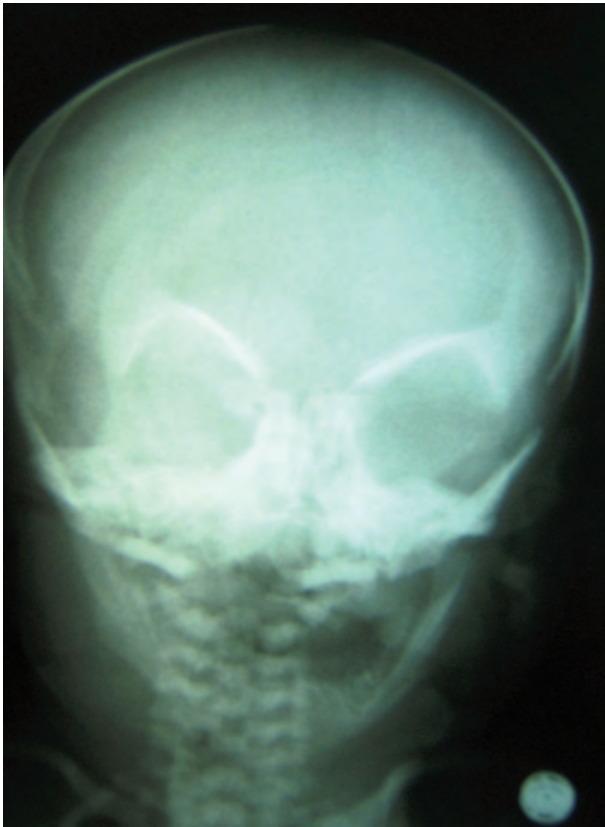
Frontal radiograph shows the appearance of "space alien" face.
